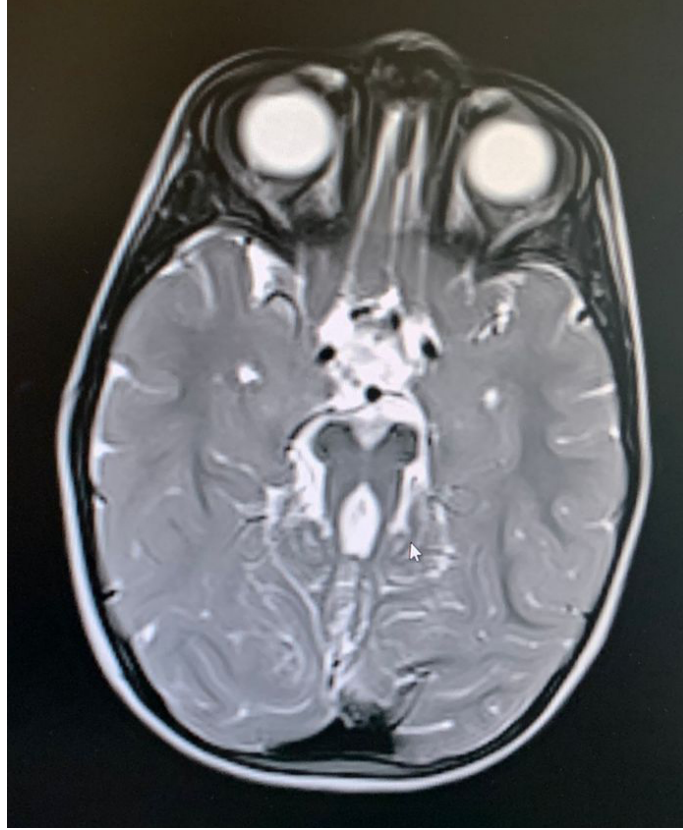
The patient's brain magnetic resonance scan (MRI) displays the molar tooth appearance.
